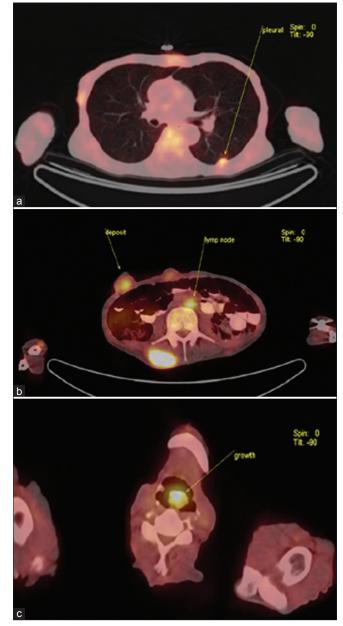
F-18 FDG PET/CT images (a) axial section in lung window showing a subpleural nodular deposit on the left side (b) axial section showing FDG avid subcutaneous deposits and FDG avid abdominal lymph node, and (c) axial section showing FDG avid lesion involving the epiglottis
